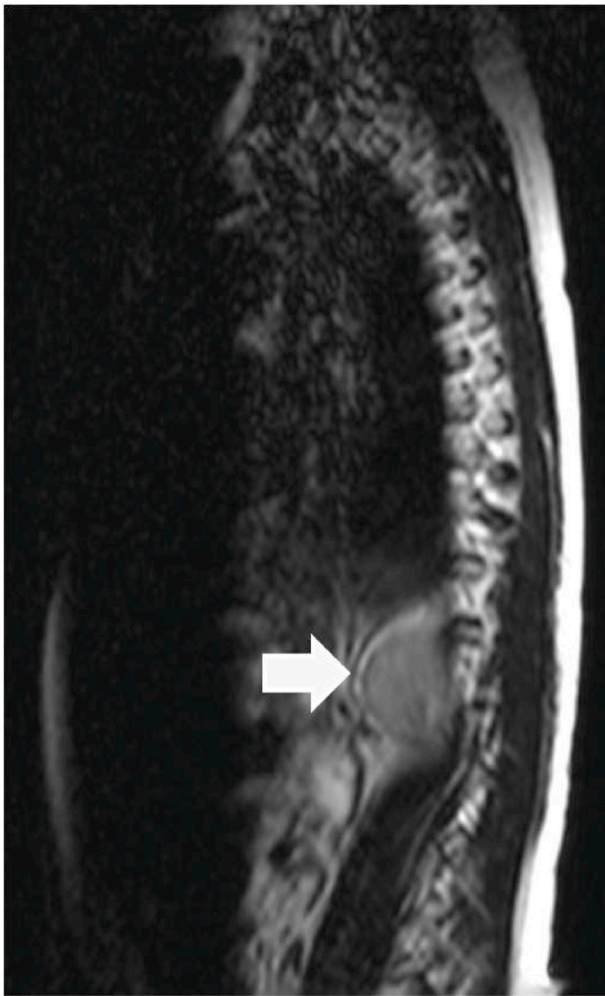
MRI showing a formation extending into the spinal cord (arrow), from T12 to L2, measuring 3,8 cm in longitudinal length and axial thickness of 1,8 cm.
